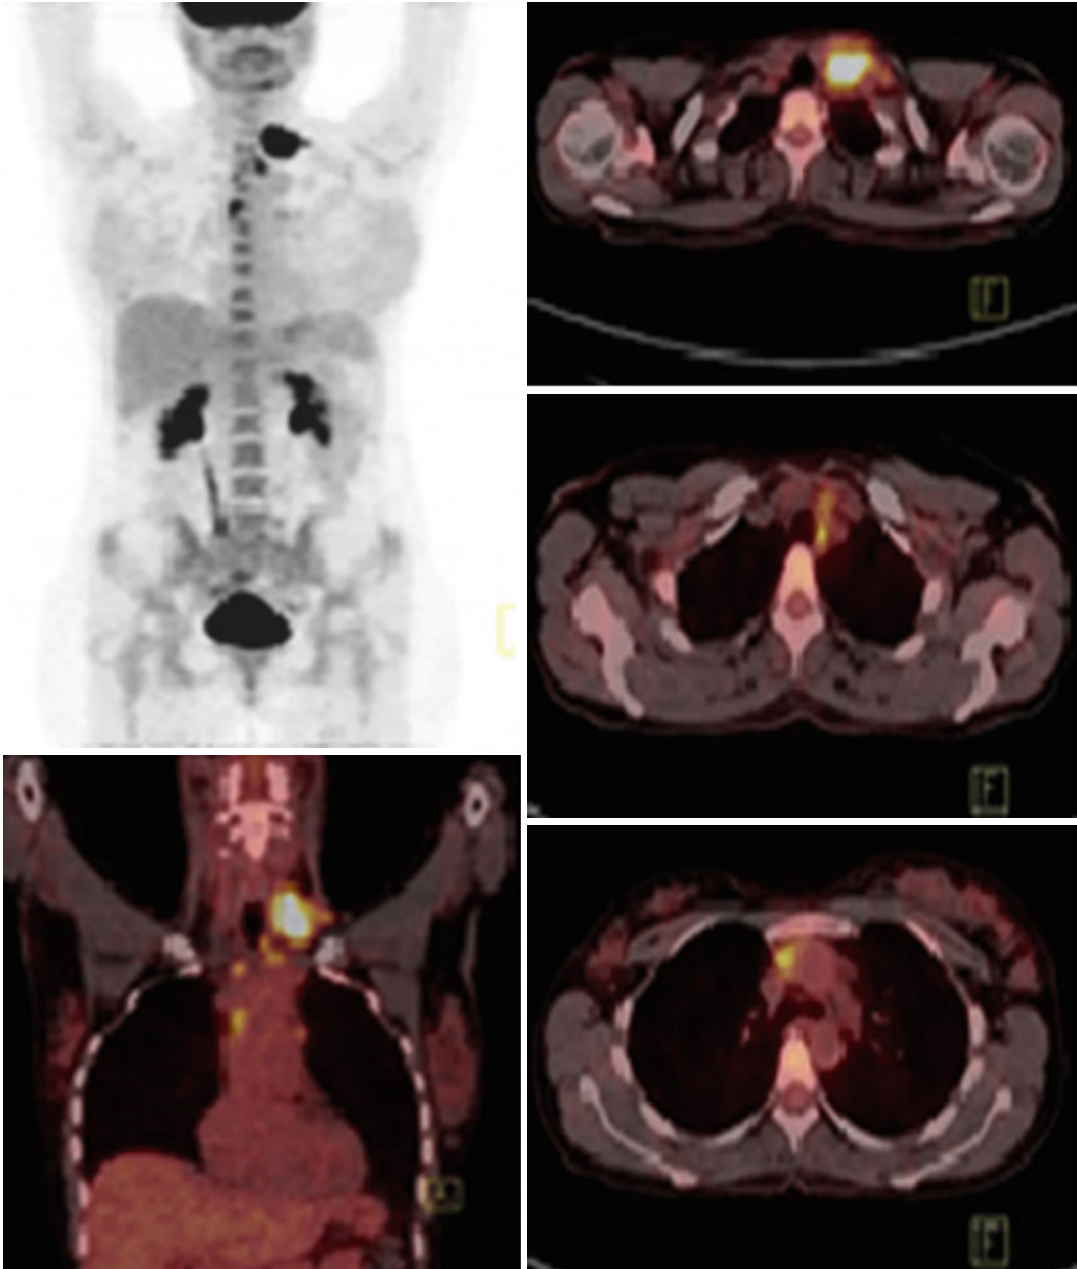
Initial staging PET/CT: hypermetabolic lesions at the left supraclavicular area (SUVmax 8.8) and the upper anterior mediastinum (SUVmax 4)
